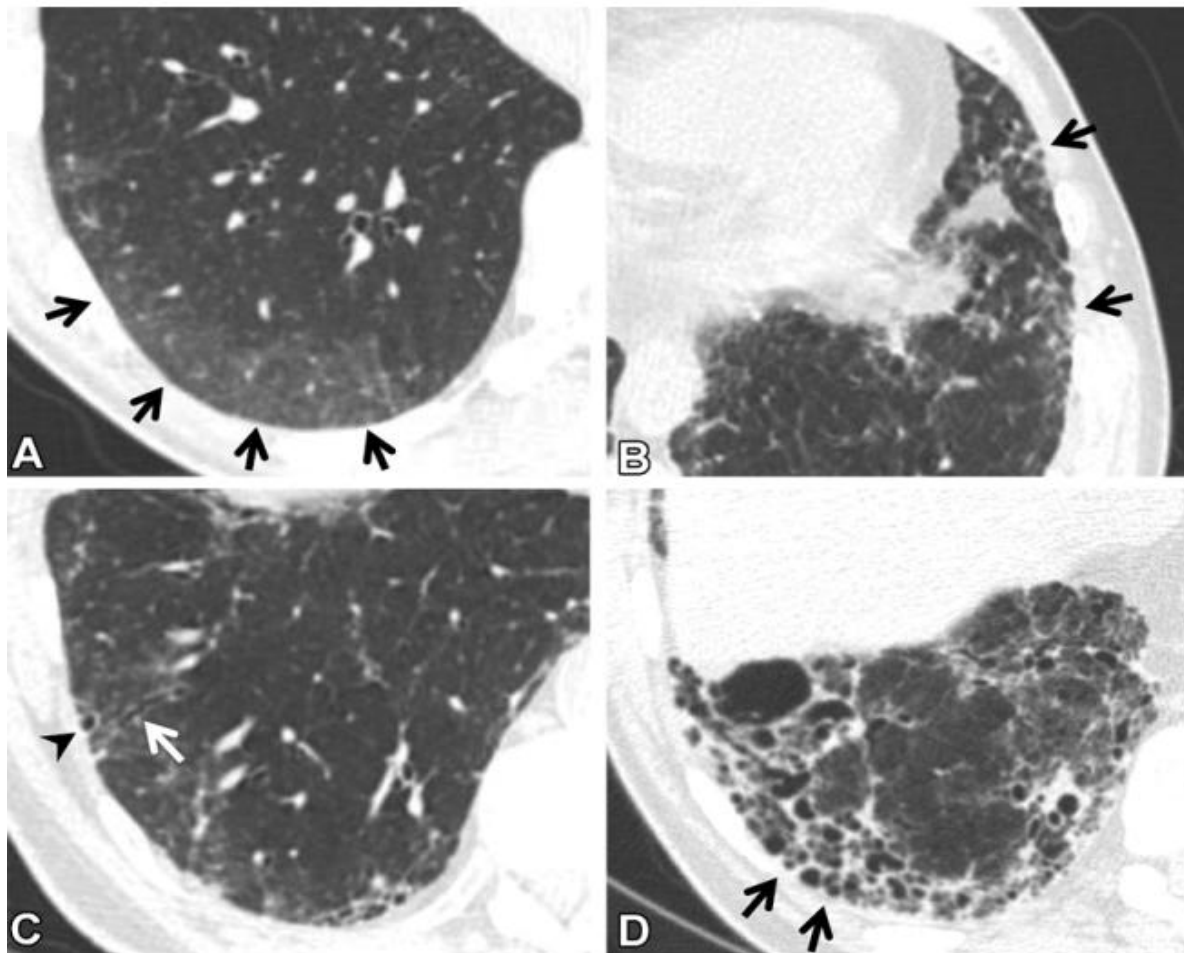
CT scan findings in ILA. Axial slices show ground-glass abnormalities (arrow in A), reticulation (arrow in B), traction bronchiectasis (arrow in C), non-emphysematous cysts (arrowhead in C), and honeycombing (arrow in D)<sup>2</sup>
